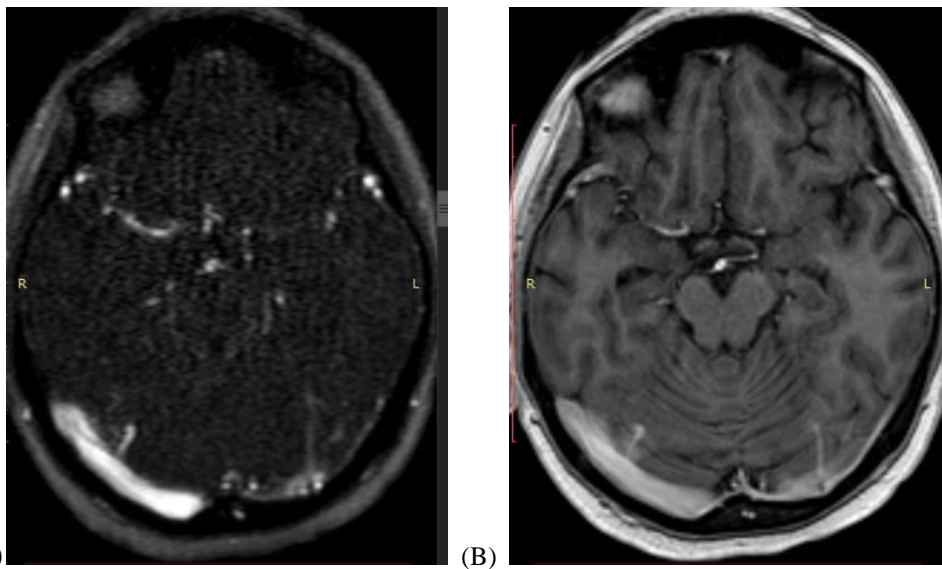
39 years old female on oral contraceptive pills develops chronic headache, the study was reviewed by conventional MRI sequences and by the image (A) MRV showing stenotic left transverse sinus with irregular filling defect at its proximal half suspecting old transverse sinus thrombosis with partial recanalization. (B) Contrast enhanced MPRAGE showing patent hypoplastic transverse sinus with nodular intraluminal filling defect appears to be arachnoid granulation.
